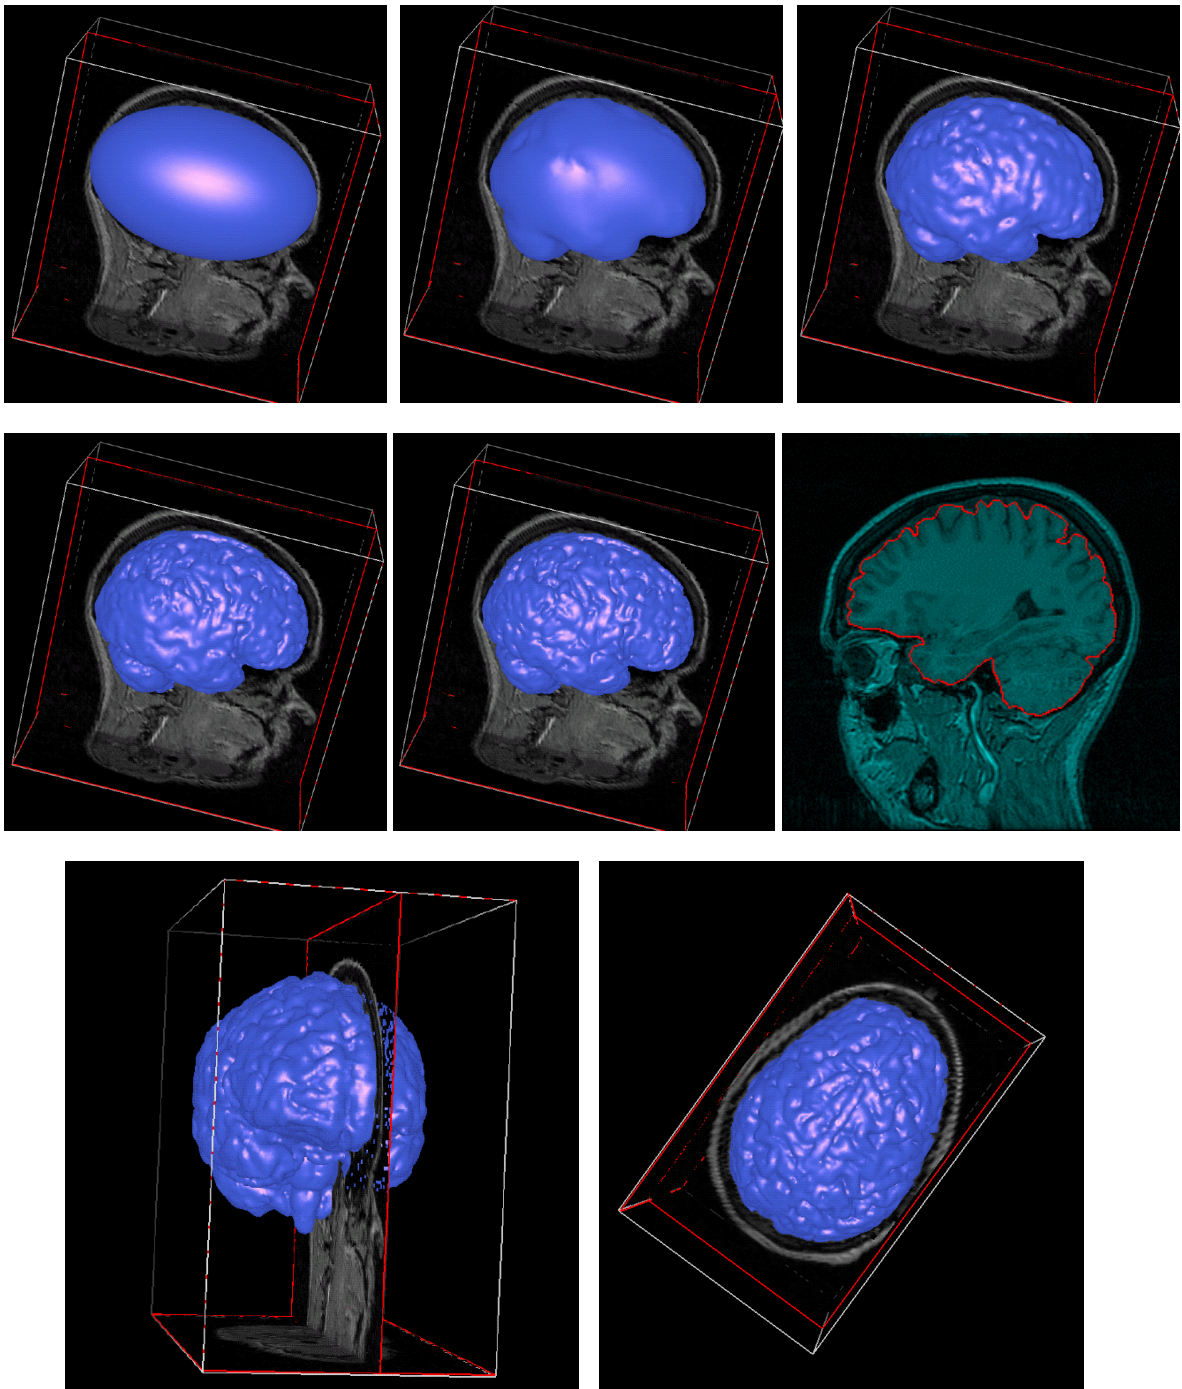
Mesh fitting process, starting from a mesh with the shape of an ellipsoid and low number of nodes. Refinement is applied to the mesh in order to add nodes in the areas where more detail is required. Different stages on the refinement-fitting process are shown in the first two rows, together with the intersection of the model with one of the slices of the MRI. Enlarged front and top views of the final model are shown in the last row.
